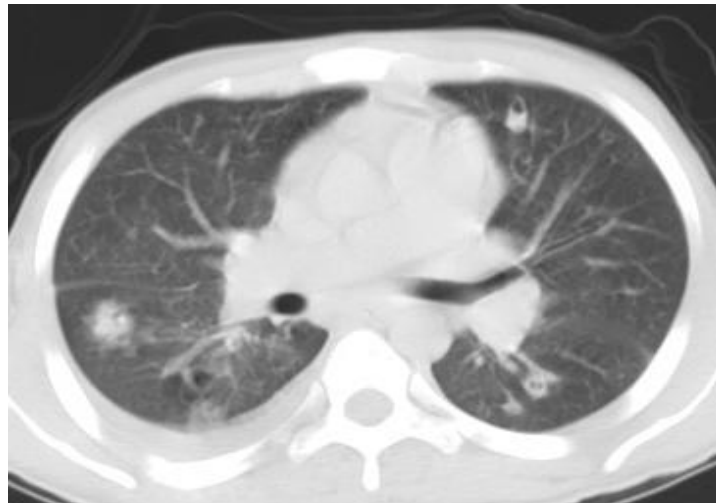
HRCT of relapsed T.B with superadded small nodular fungal infection some of these small nodules showing cavitation.
